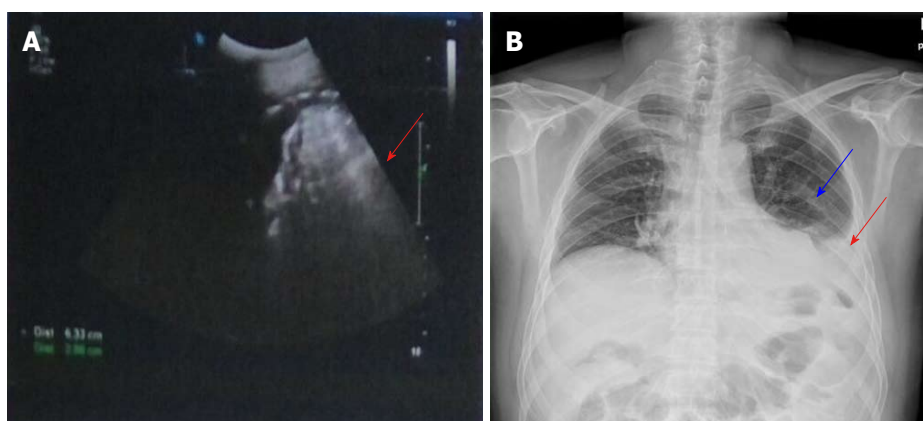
Abdominal B-ultrasonography findings. A: Abdominal B-ultrasonography showed a limited non-echo area (about 6.3 cm × 2.9 cm in diameter) in the splenic fossa area, which suggested effusion in this area (arrow); B: Chest x-ray revealed a high density in the left lower chest (blue arrow), the left diaphragm angle was unclear, and a moderate volume of pleural effusion was seen in the left side of the chest (red arrow).
